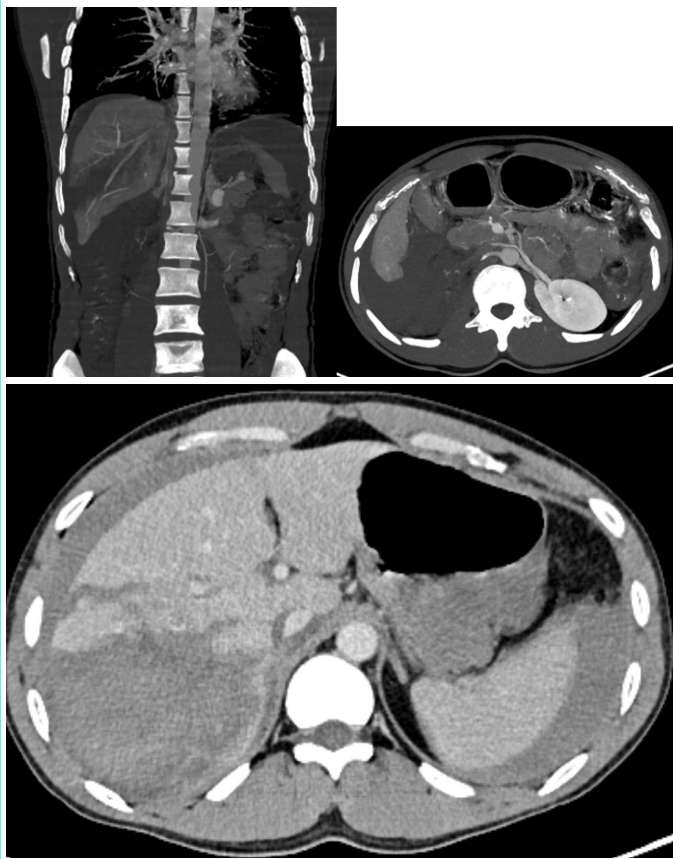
Coronal and axial CT scan showing the right renal devascularization (red arrow), a right adrenal hematoma (yellow arrow), the hepatic injury (green arrow), and anhemoperitoneum (blue arrow).
